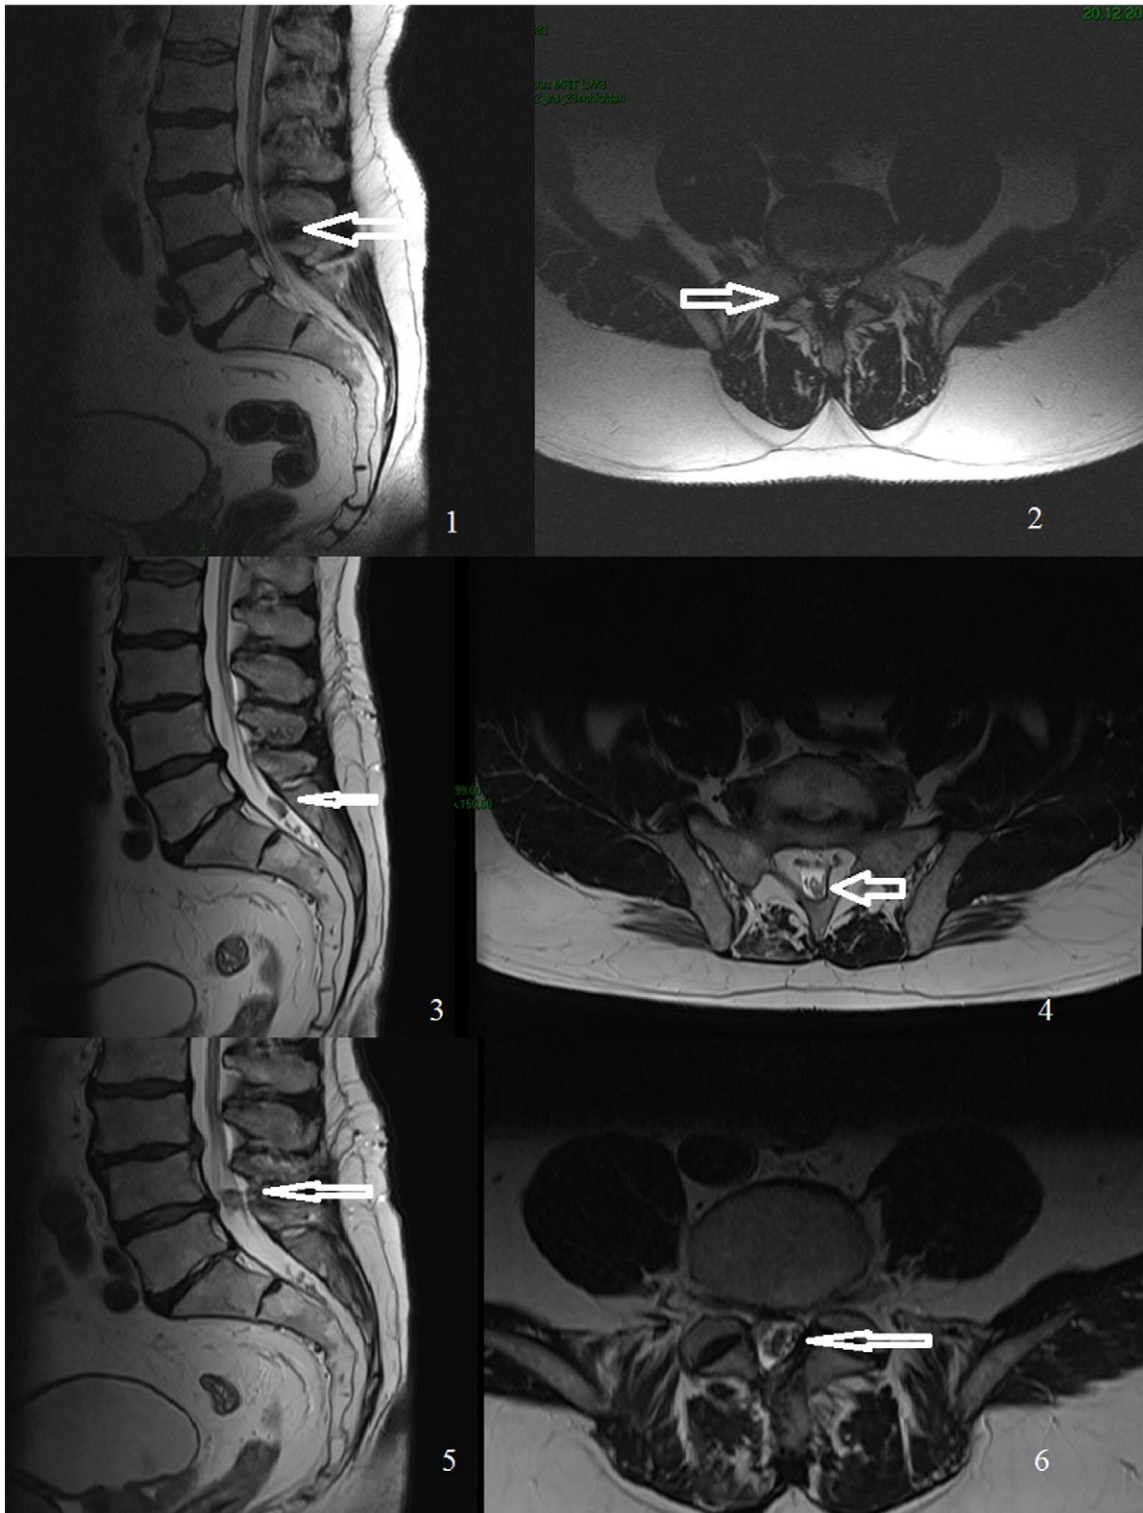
Preoperative MRI showing a disc herniation at level 4/5 re, 3 & 4 MRI after seven months from surgery showing an intradural mass at the level S1, 5 & 6 2-years after the surgery showing the same position of the intradural disc herniation.
